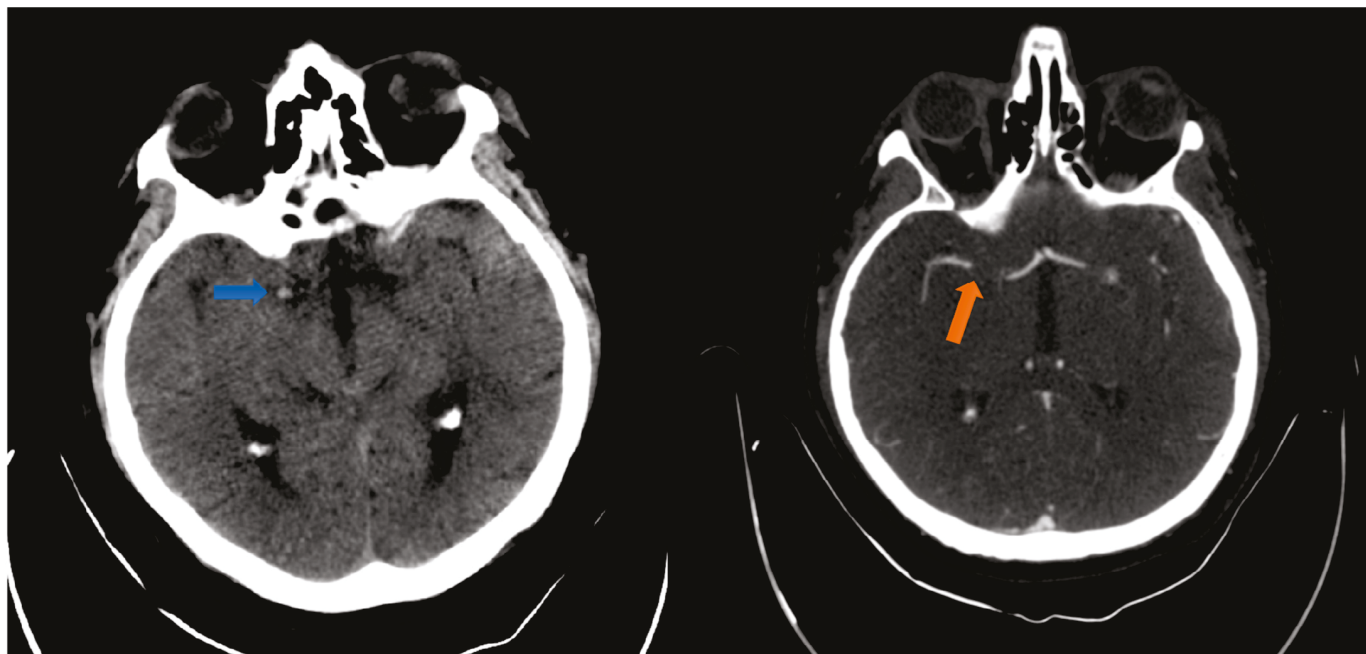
The left image displays the initial CT scan of the head, revealing no significant indications of ischemic or hemorrhagic events. The PC-ASPECTS score was 10. A hyperdense right middle cerebral artery is visible, indicated by a blue arrow. The right image shows a multiphase head angiography-CT, confirming the presence of a thrombus at the level of the MCA as segment M1, as indicated by a red arrow.
